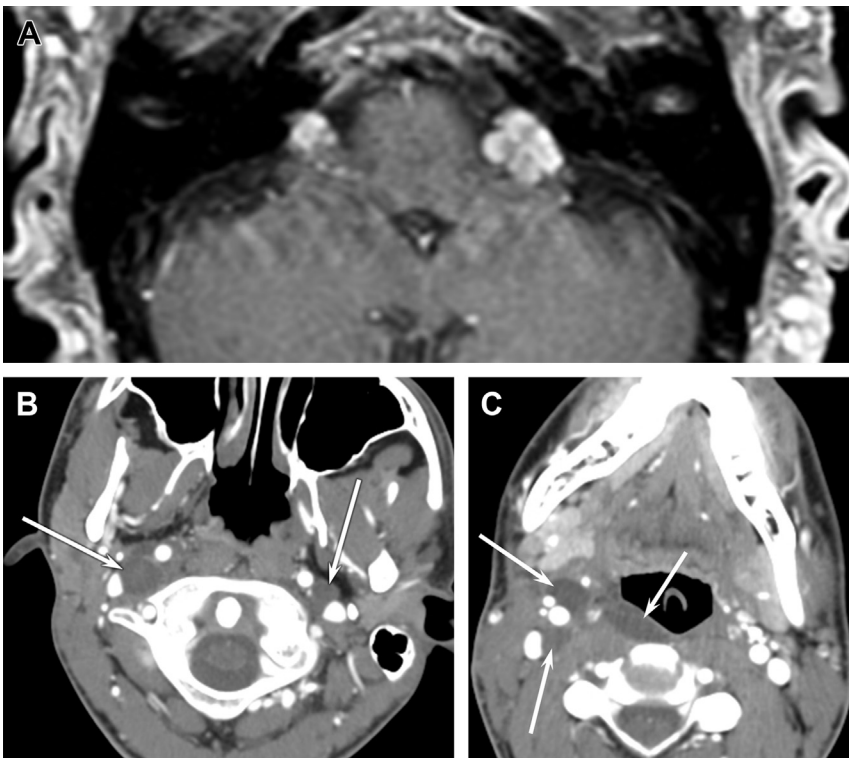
Neurofibromas of the lower CNs. (A) Axial-enhanced T1-weighted image shows bilateral enhancing masses along the expected course of the lower CNs. (B) Axial-enhanced CT shows bilateral nonenhancing masses (arrows) at the expected location of the vagus nerves. (C) Axial-enhanced CT shows plexiform configuration to a nonenhancing mass (arrows) with involvement of the carotid and retropharyngeal spaces.
